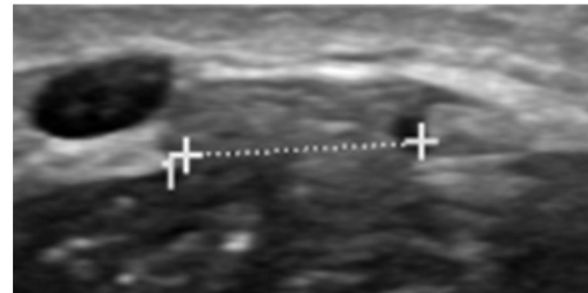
Axial ultrasound image of forearm showing loss of continuity of hyper-echogenic fascia with herniation of muscle belly.
